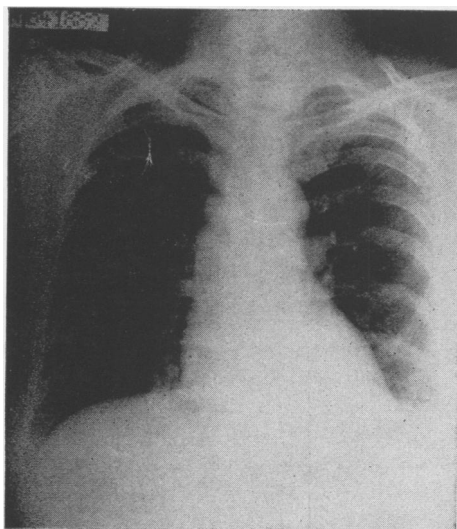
Case 4. P. A. Roentgenogram showing lesions at both lung bases.
